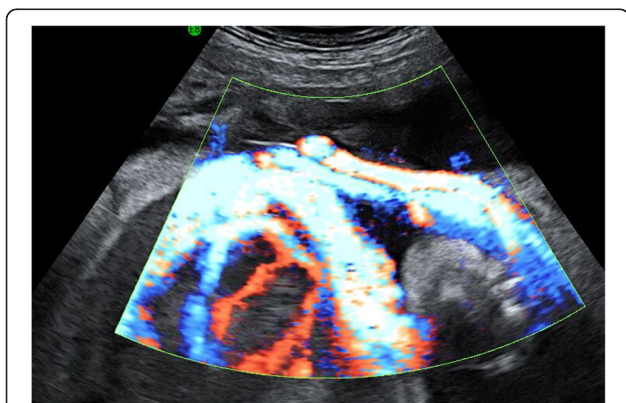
Color Doppler of giant placental chorioangioma.
